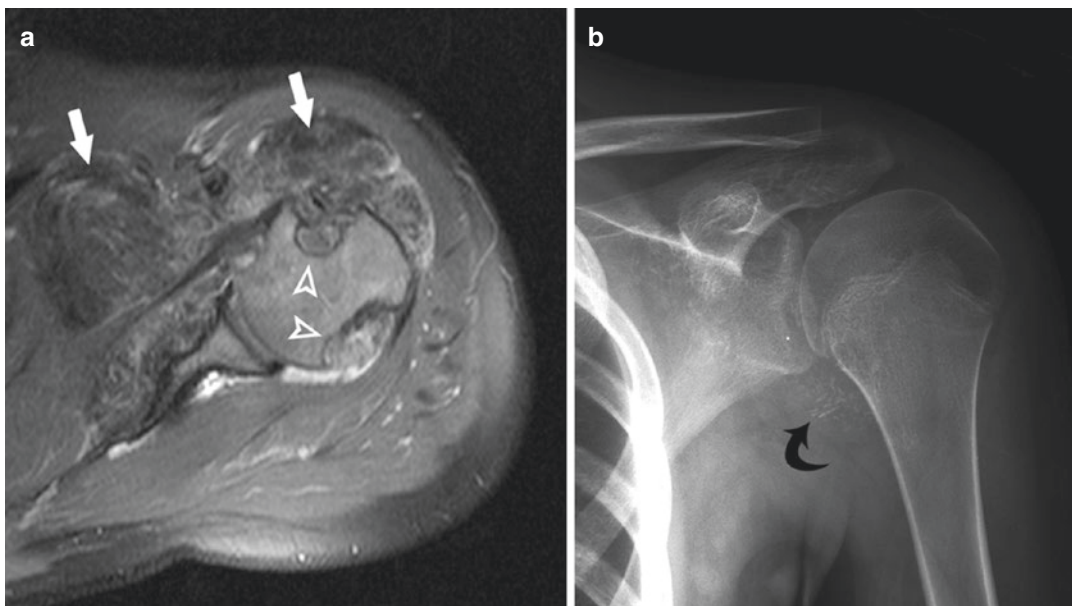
Intra-articular lesions: (a) Pigmented villonodular synovitis demonstrated on axial T2-weighted sequence with fat saturation. The mass reveals a predominantly low-signal-intensity lesion (arrows) with preferential shortening of T2 relaxation time caused by hemosiderin.
